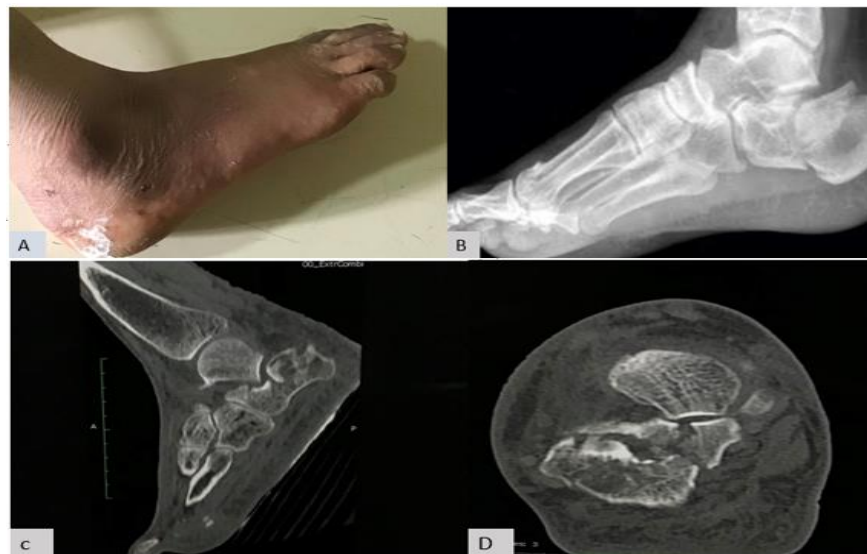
A. Image depicting the Swelling of ankle. B. X-ray lateral view depicting the fracture of the Calcaneum. C/D. Saggital and Axial Images revealing the comminuted fracture of the Calcaneum with intra-articular extension.
